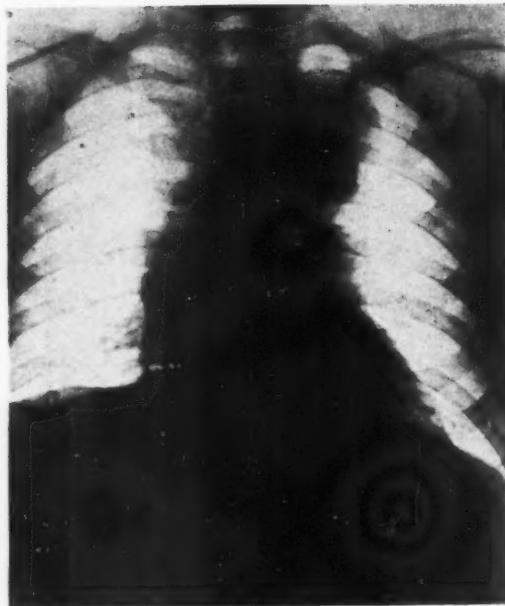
Chest x-ray showing typical barrel-shaped aortic shadow with shadow of aneurysm extending through stomach air bubble.
